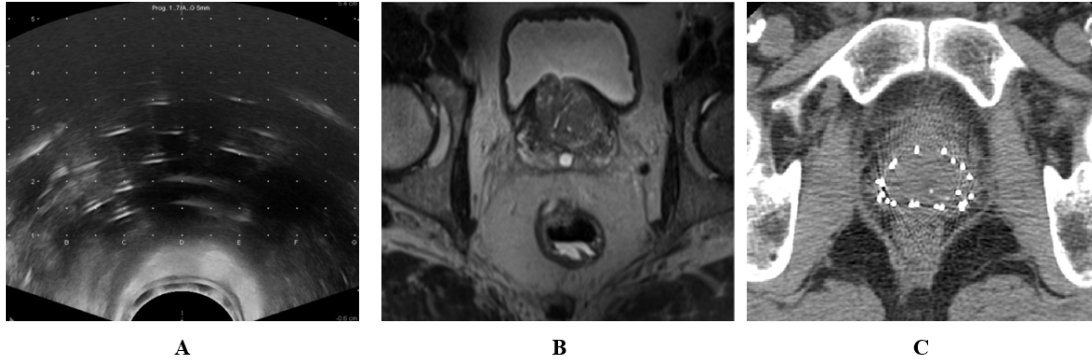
Examples of prostate gland images obtained from: (A) TRUS, (B) MRI, and (C) CT. A brachytherapy grid was superimposed over the original ultrasound images that appeared as white dots on the TRUS images.
